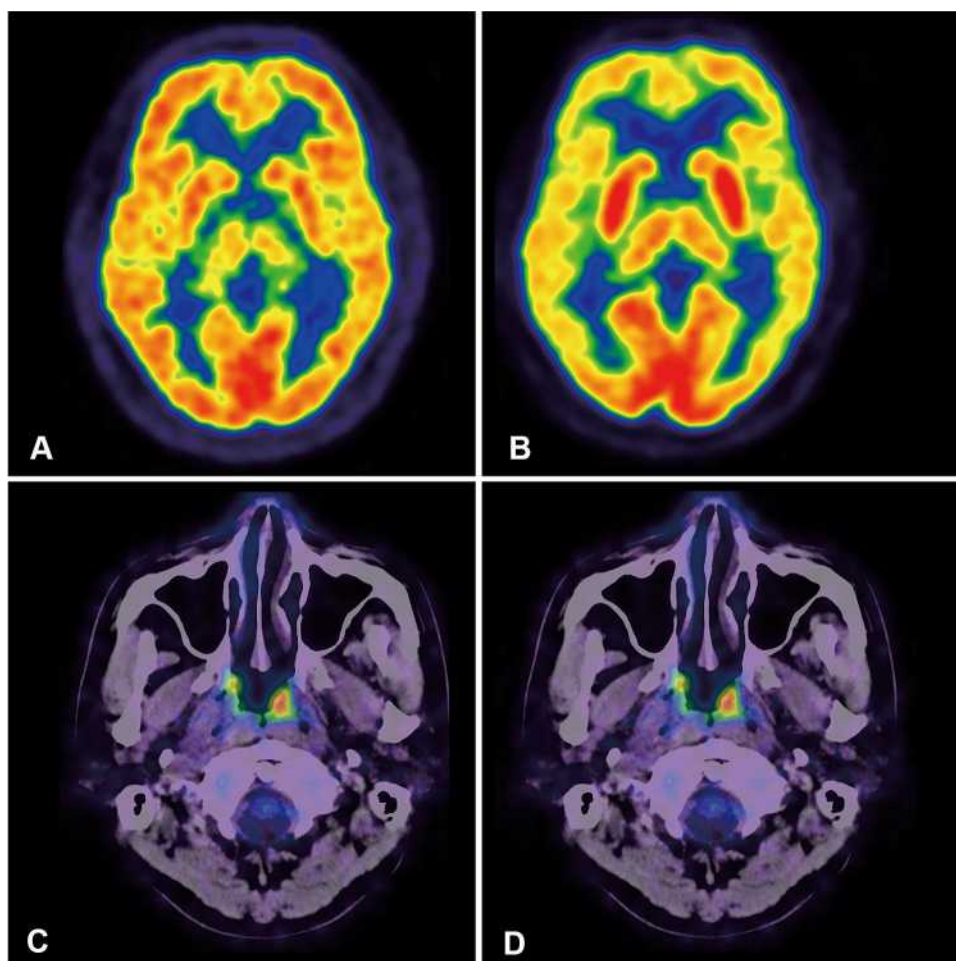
Cerebral ¹⁸F-FDG Metabolism of a healthy control (A) and a patient (B–D). A 53-year-old male underwent ¹⁸F-FDG PET/CT (A) during a health check, which showed relatively symmetric cerebral ¹⁸F-FDG metabolism. No obvious abnormal metabolism was observed. ¹⁸F-FDG metabolism in the basal ganglia was similar to that in the cortex. A 58-year-old male was diagnosed with stage II nasal type ENKTL, and pretreatment ¹⁸F-FDG PET/CT revealed soft tissue in the left nasal cavity (C) and swollen lymph nodes in the right neck (D) with increased ¹⁸F-FDG uptake. His pretreatment TLG was 36.9. Brain ¹⁸F-FDG PET images demonstrated prominent hypometabolism in the bilateral frontal, parietal, and temporal cortices, with relative sparing of the occipital cortex. The metabolism of the bilateral basal ganglia was prominently higher than the cortex (B). The patient had been disease free for 30 months at the end of follow-up.
